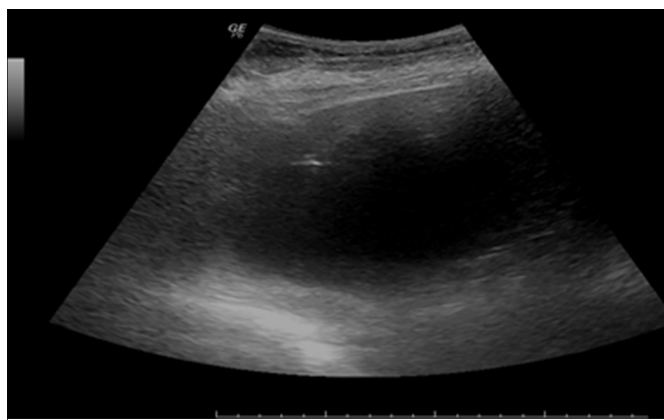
A 15x20 cm giant cyst located under the right side of diaphragm in sonography.
